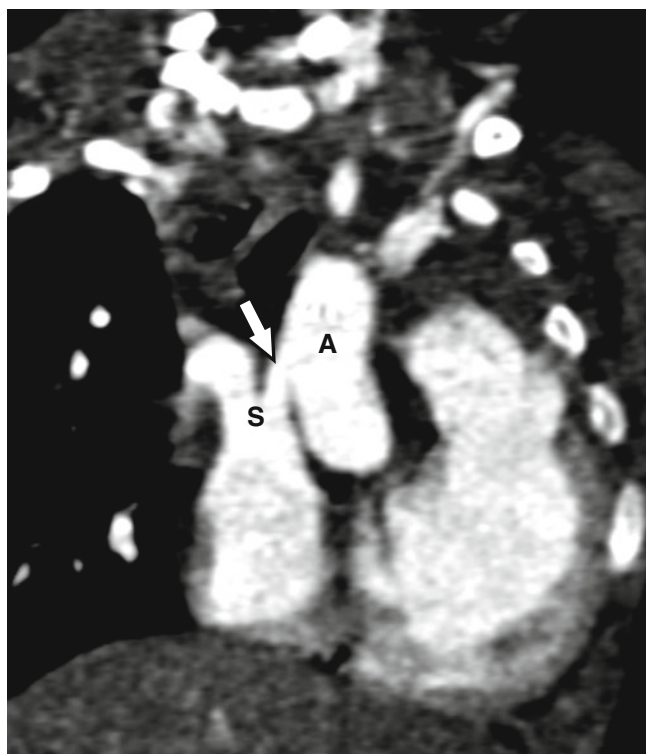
Cardiac motion artifact in non-gated cardiac CT. The cardiac CT without gating is prone to motion artifacts. The aorta and superior vena cava seem connected, but this is a motion artifact from a heartbeat. However, the pulmonary arteries and pulmonary veins and aorta, except for the ascending aorta, can be imaged by a non-gated cardiac scan because the cardiac motions in those structures are not significant
